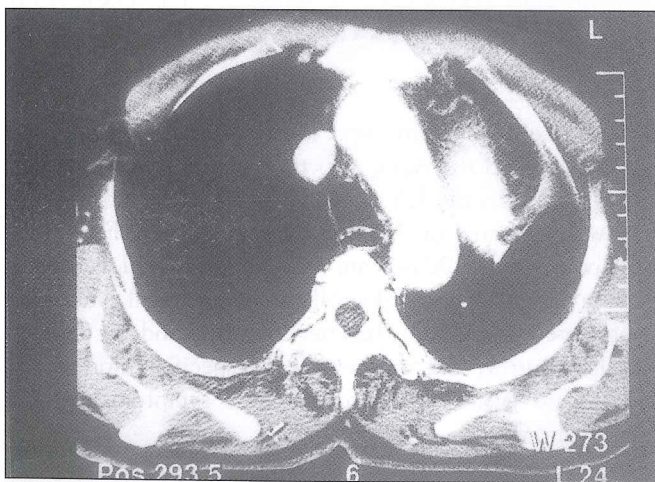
Thorax computed tomography showing many enlarged collateral vessels.
